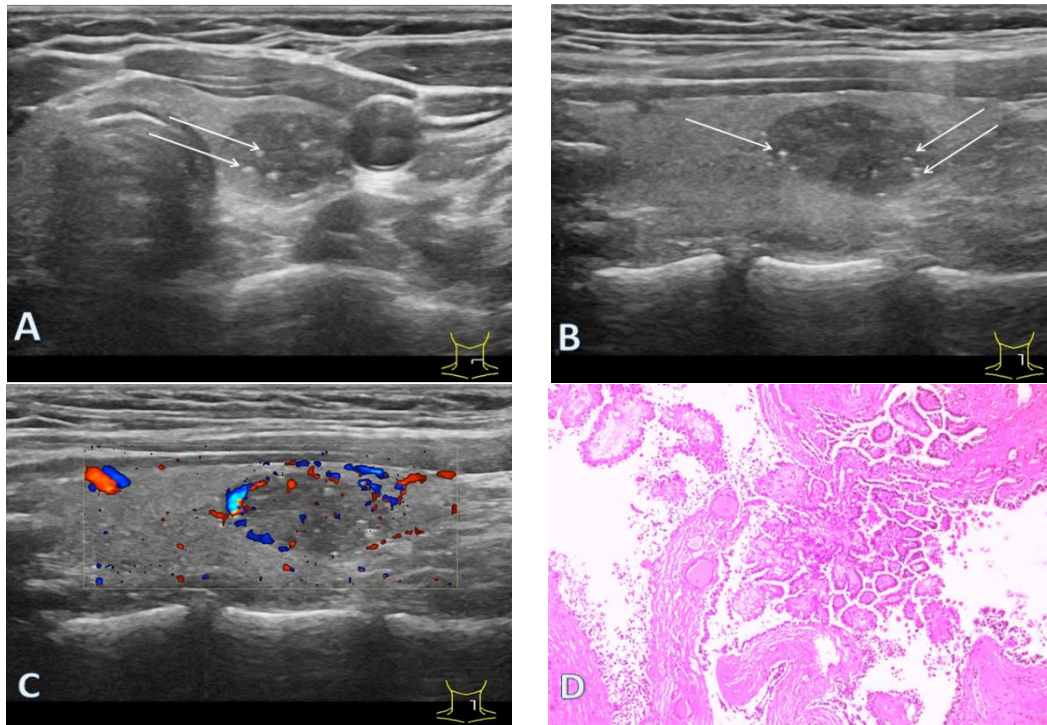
Ultrasonography of PTC combined with cystic degeneration in a 31-year-old female patient.
